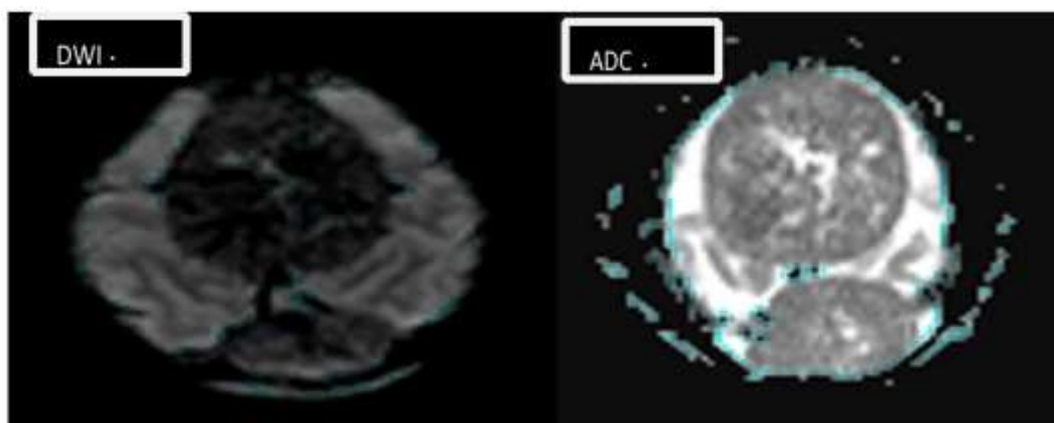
coronal section of hemangiopericytoma on T1W and T2W images and axial section on DWI and ADC
